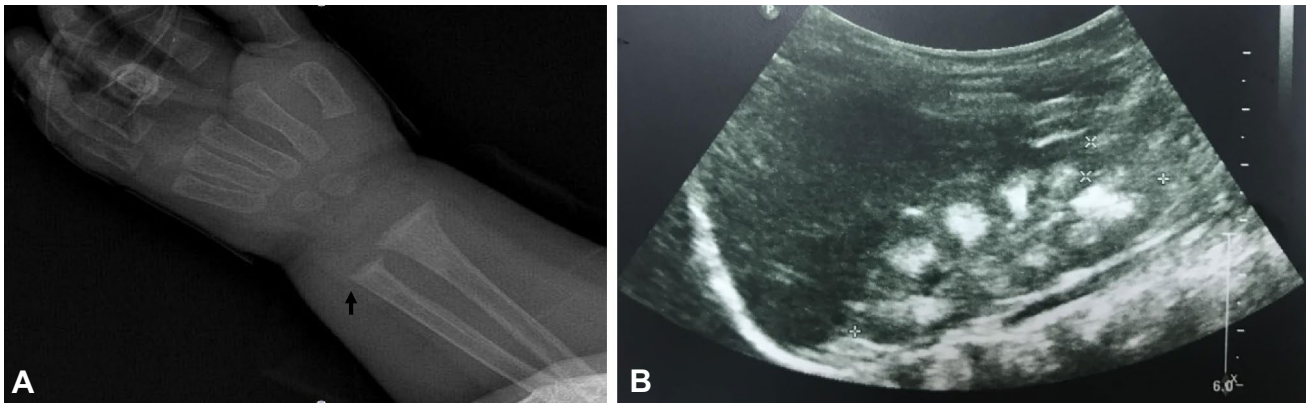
Hand radiograph of Pt #2 showing cupping and fraying of the metaphysis (A) and nephrocalcinosis on ultrasound at initial presentation (B)
